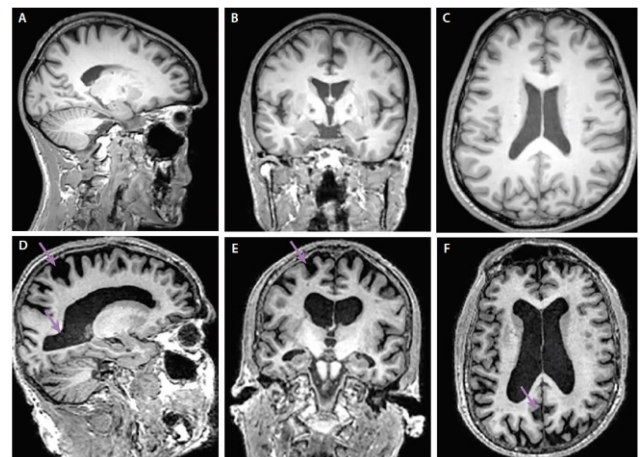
MRI scans showing clear difference between normal control (A, B, C) and severely demented brain (D, E, F)
